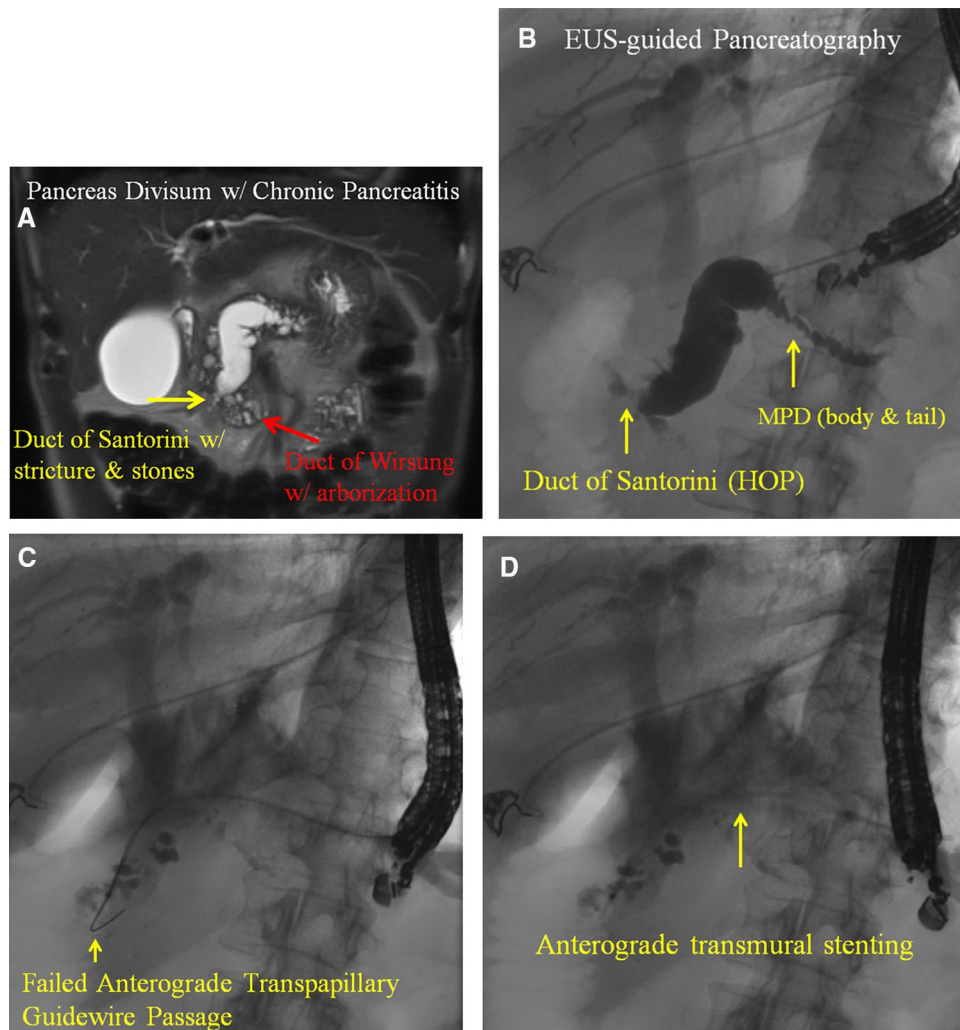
a Magnetic resonance cholangiopancreatography (MRCP; coronal view; T2-weighted) demonstrating pancreas divisum with chronic pancreatitis. The duct of Santorini is extremely dilated to 1.4 cm. A ductal narrowing (outflow obstruction) is present near the minor papilla (yellow arrow). The proximal MPD is tightly strictured. The duct of Wirsung, in the setting of pancreas divisum, is identifiable by its arborization (red arrow). b Fluoroscopic view of EUS-guided pancreatography. Transgastric puncture of the MPD, and pancreatography, is performed using a 19-gauge aspiration needle and contrast medium, diluted 1:1 with sterile water. An outflow obstruction is present in the duct of Santorini adjacent to the minor papilla (labeled), with upstream dilation of the MPD to 1.4 cm.
